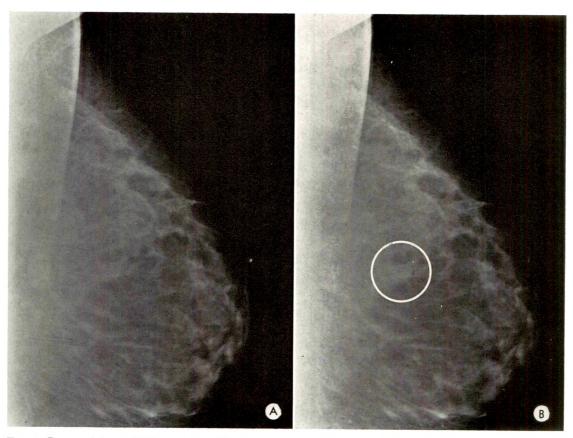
Case II. (A and B) Two comparative lateral mammograms 3 months apart, in a 45 year old female with localized pain and tenderness, but no definite mass. The minimal increase in size of a dominant roentgen shadow indicated the advisability of an area dissection. Localization technique was performed to guide the surgeon.
